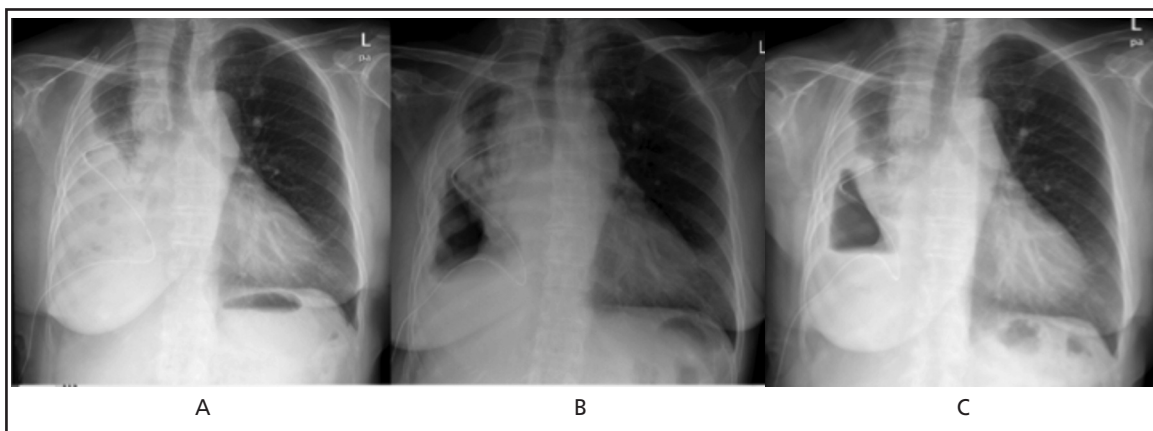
Chest radiograph (A) showed loculated right pleural effusion with IPC tip in-situ. Chest radiograph (B) showed minimal effusion after 5 doses of alteplase instillation with non-expandable lung. Chest radiograph (C) post alteplase showed no recurrence of loculated effusion.
